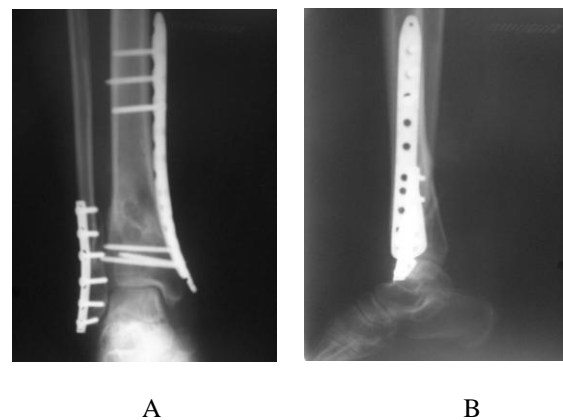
Postoperative anteroposterior (A) and lateral (B) radiographs at 3 months demonstrated complete bone healing
